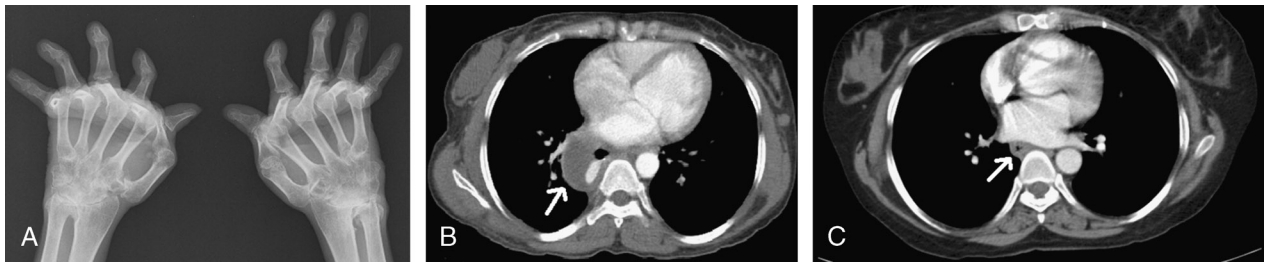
A, X-ray of the hands showing characteristic radiologic features of RA. B, Computed tomographic images of the thorax demonstrating asymmetric circumferential wall thickening of the esophagus (white arrow), proximal esophageal dilatation, and periesophageal extension. C, Repeat CT images of the thorax 15 months after initiation of therapy showing significant reduction in the degree of the wall thickening and proximal luminal dilatation (white arrow).
